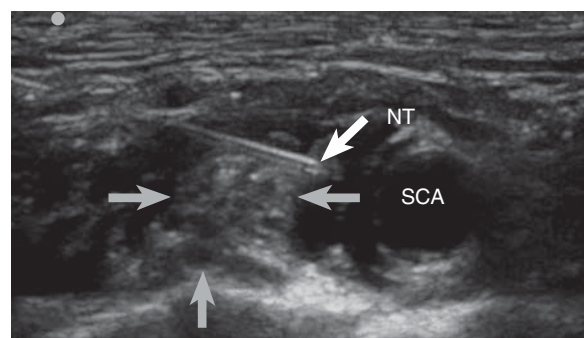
Ultrasound scan of the brachial plexus at the supraclavicular level using an 'in-plane' technique. The brachial plexus is labelled with grey arrows and lies directly above the cervical pleura. The hypoechoic area around the brachial plexus was created by the injection of 8 ml of local anaesthetic solution. NT, needle tip; SCA, subclavian artery.
